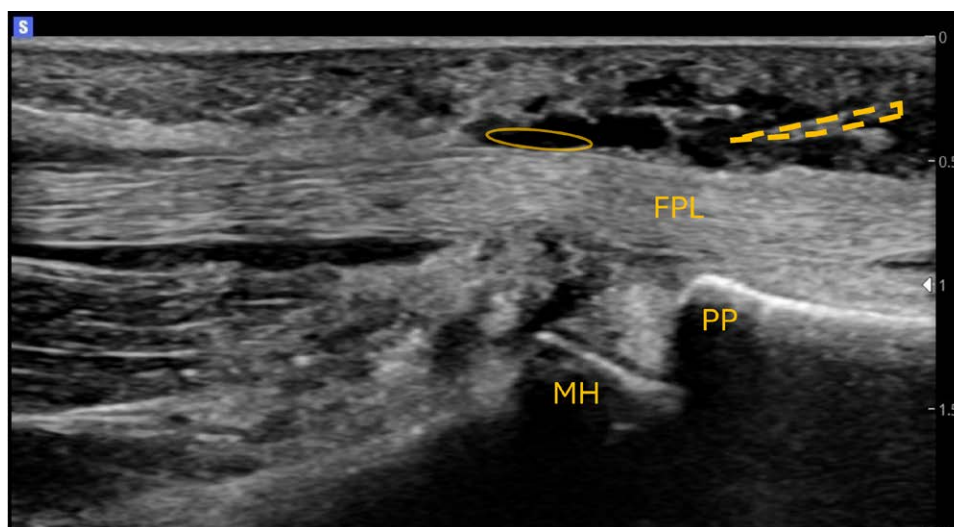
Long-axis ultrasound view of flexor pollicis longus (FPL) at the metacarpophalangeal joint (proximal phalanx, PP, and metacarpal head, MH) after A1 pulley release showing empty space where the A1 pulley was previously located (oval overlay).
